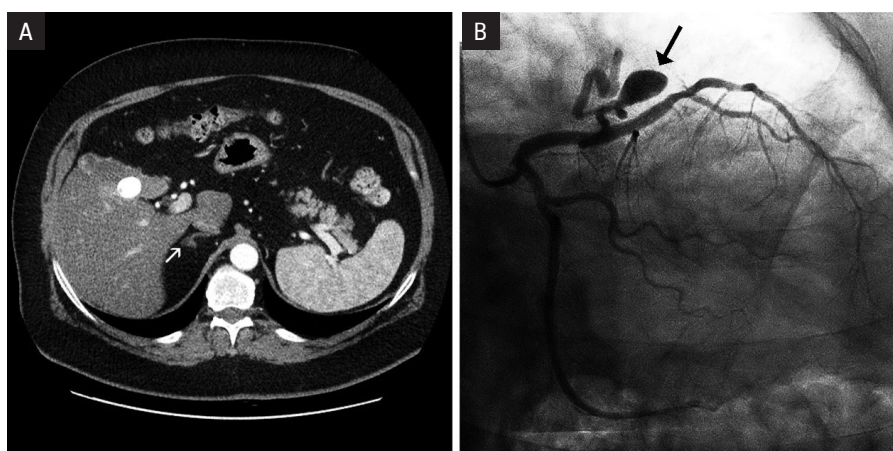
Transverse CT scan of the abdomen showing a nodule in the lateral limb of the right adrenal gland (Arrow) compatible with the adenoma measuring 7 mm (A). Coronary angiogram clearly showing a coronary artery fistula (Arrow) between the proximal left anterior descending artery and the pulmonary artery (B)
